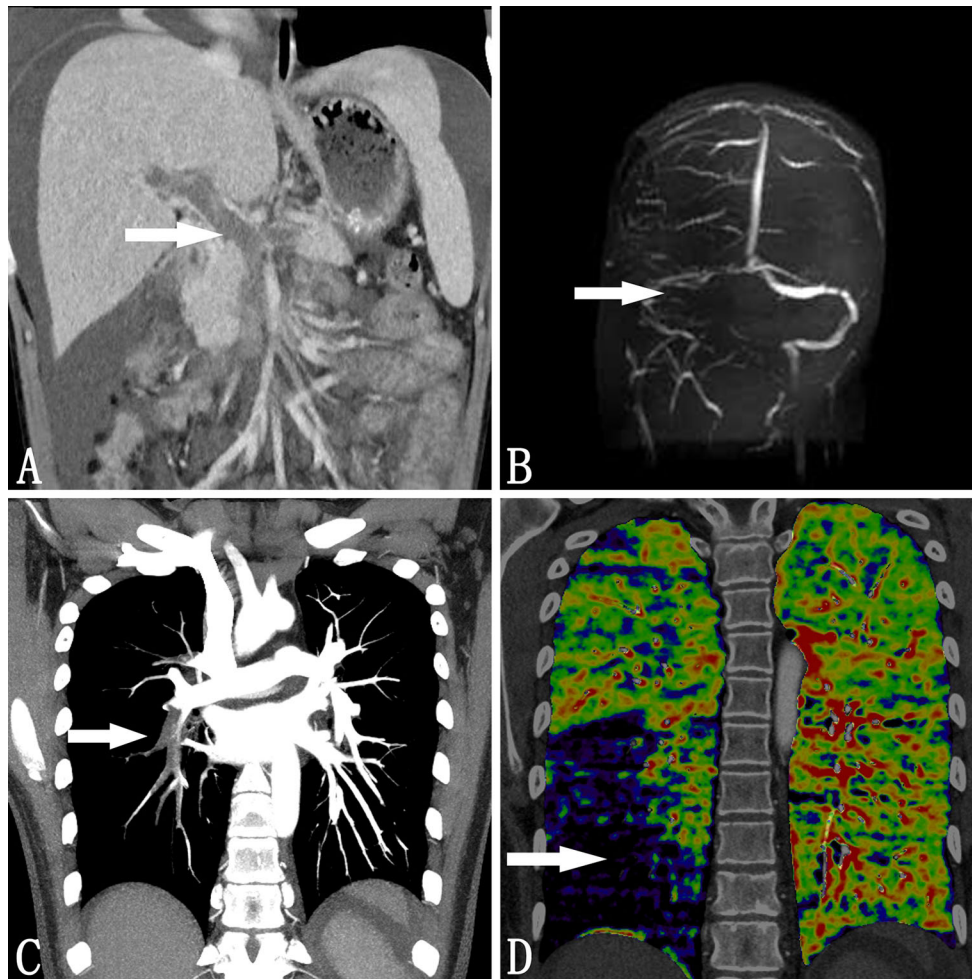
Localization of VTE and PE in FSGS patient. a CT venography image shows the filling defect in the trunk of the portal vein (*arrow*) case 2. b Contrast-enhanced MR venography image shows the filling defect in the right sigmoid sinus (*arrow*) case 9. c Coronal reformatted CT pulmonary angiography image showed right inferior
